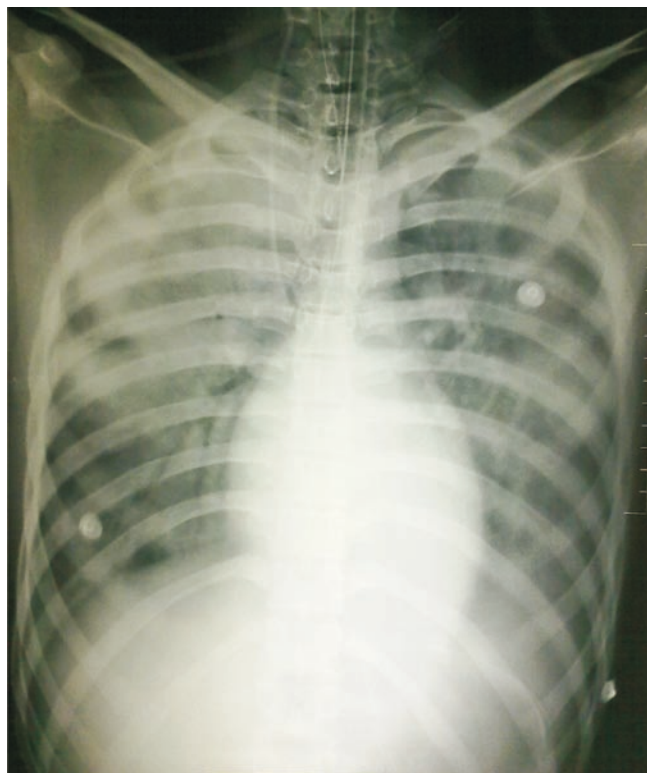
Chest radiograph on day 1 revealing asymmetrical right upper and mid zone alveolar infiltrates with air bronchograms.
